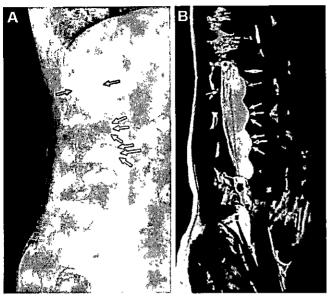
Dural ectasia in a 6-year-old boy with NF1 (same patient as in Fig 9). Lateral radiograph (A) and sagittal T2-weighted MR image (B) of the lumbar spine show dilatation of the lumbar spinal canal (red arrows) with posterior scalloping of the lumbar vertebral bodies (white arrows).
